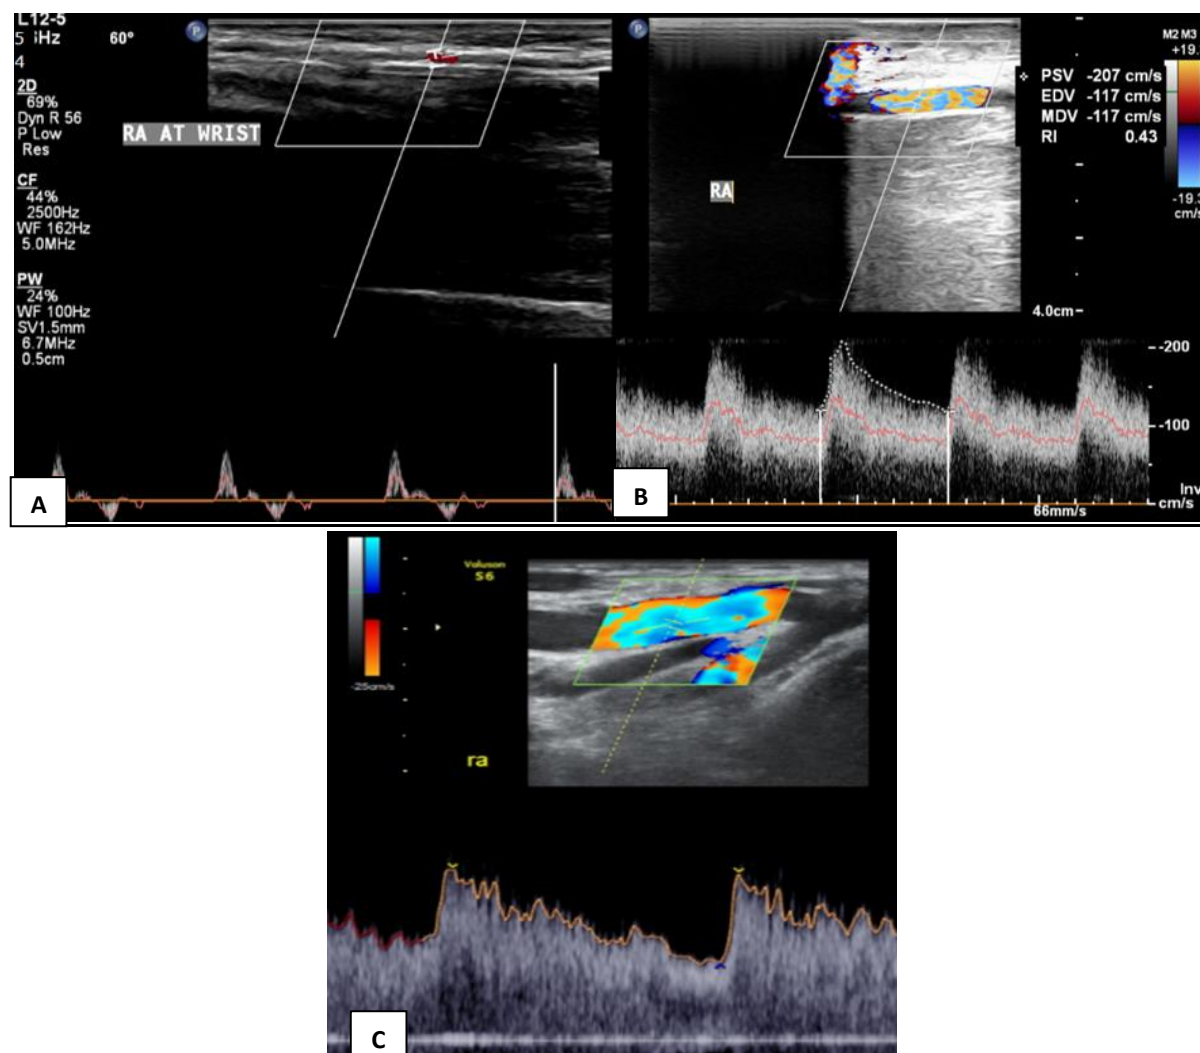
A 43 year old male with history of diabetic nephropathy. (A) Colour Doppler US of radial artery pre-operatively shows radial artery PSV of 57 cm/s. (B) Colour Doppler US of radial artery during the immediate post-operative period (0-14 days) show a PSV of 207 cm/s. (C) Similarly PSV at 6 weeks is 323 cm/s.
